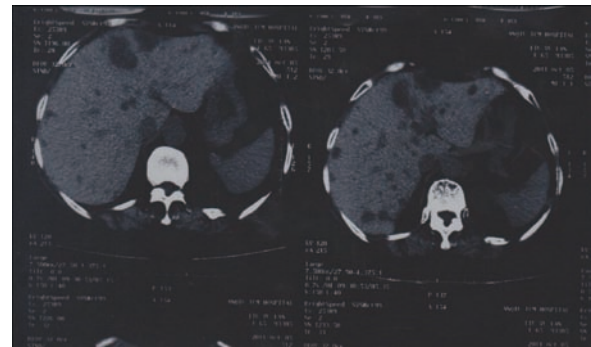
After 2 years of Cryotherapy and traditional Chinese medicine treatment, strengthen CT showed that hepatic tumor, the former has improved markedly. And survival with tumor, with follow-up 3 years, patients have a normal life.
